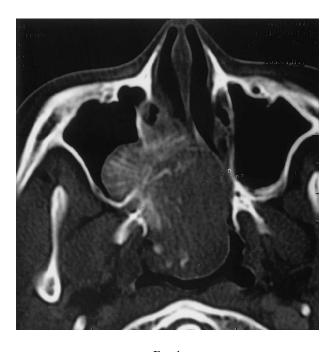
Axial CT scan on bone settings showing the tumour with 'sun ray' spiculation arising from the medial wall of the right maxillary antrum.
